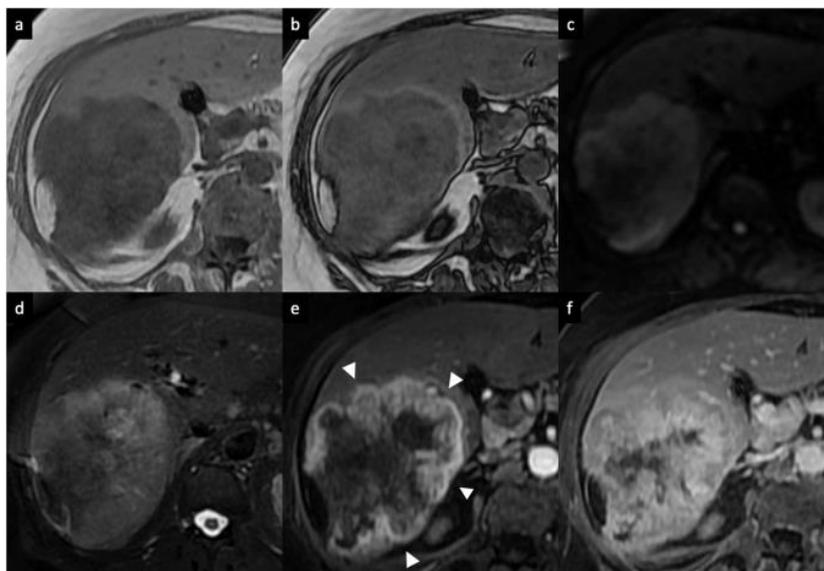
Intrahepatic mass-forming cholangiocarcinoma in a 62-year-old woman. a Axial T1-weighted in-phase and (b) opposed-phase MR images show a large lobulated hypointense mass, (c) with high SI on DWI ($b = 800$), (d) slightly hyperintense on fat-suppressed T2-weighted images, with associated capsular retraction. e Extracellular contrast agent-enhanced MRI sequences demonstrate a thick irregular rim APHE (arrowheads), (f) with progressive central enhancement on DP [50].
